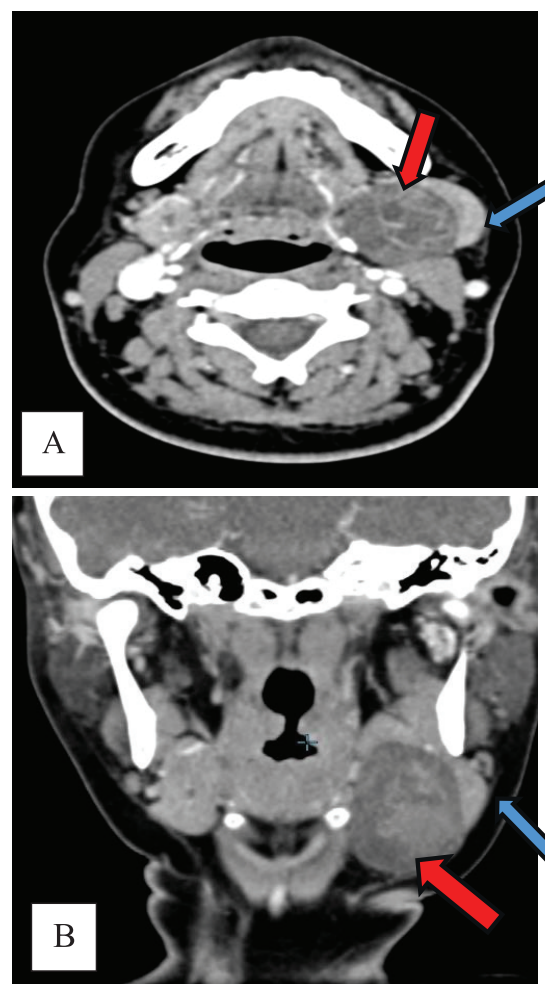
Contrast-enhanced CT of head and neck (A: axial view, B: coronal view): red arrow showing a well-defined heterogenous lesion measuring $3.4 \text{ cm} \times 3.1 \text{ cm} \times 4.5 \text{ cm}$ arising from left submandibular gland (blue arrow).
